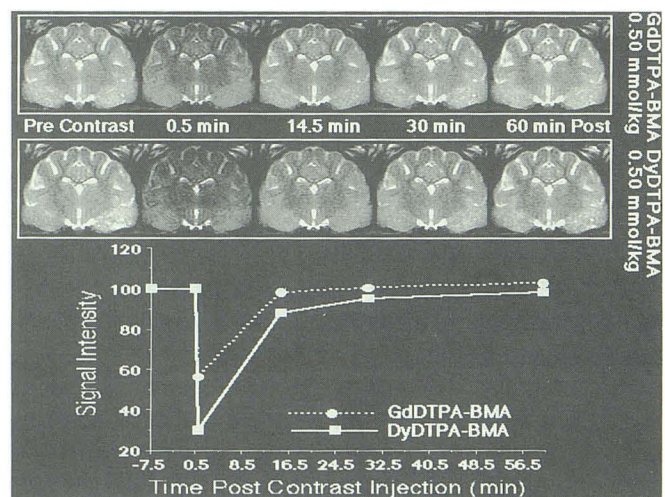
On T2-weighted images acquired 45 sec after contrast administration, intravenous injection of 0.5 mmol/kg DyDTPA-BMA produced a maximum measured signal intensity loss in cortical gray matter 70% below precontrast baseline values. Signal intensity changes in white matter (internal capsule) were smaller, consistent with the higher cerebral blood volume fraction in gray matter. The same dose of GdDTPA-BMA produced a maximum signal loss 42% below baseline levels. Restoration of precontrast signal intensity was observed within 32.5 min following injection of either contrast agent.
